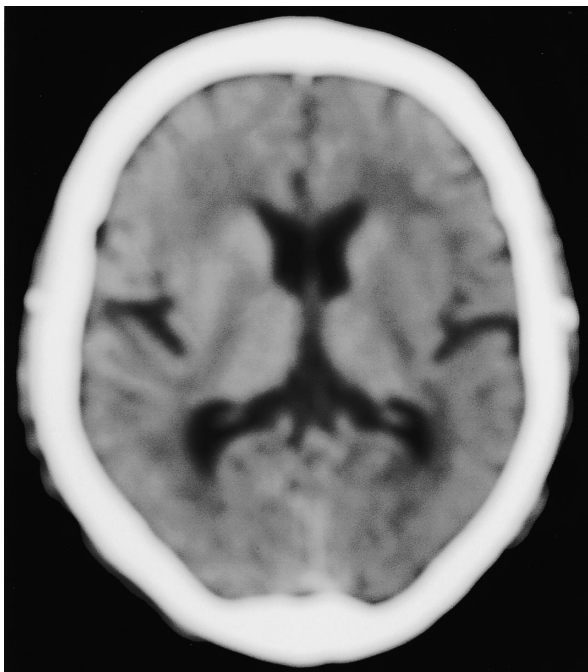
Brain computed tomography scan just after convulsion showing no signs of infarction or hemorrhage
